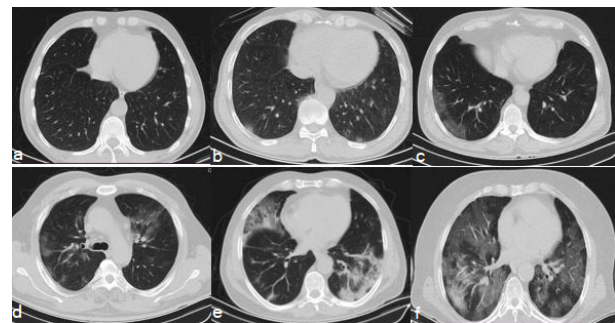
Lung parenchyma obtained from CT scans. Each of the five lung lobes were visually scored between 0 and 5: (a) no involvement; (b) $< 5\%$ involvement; (c) 5-25% involvement; (d) 26-49% involvement; (e) 50-75% involvement; and (f) $> 75\%$ involvement.
